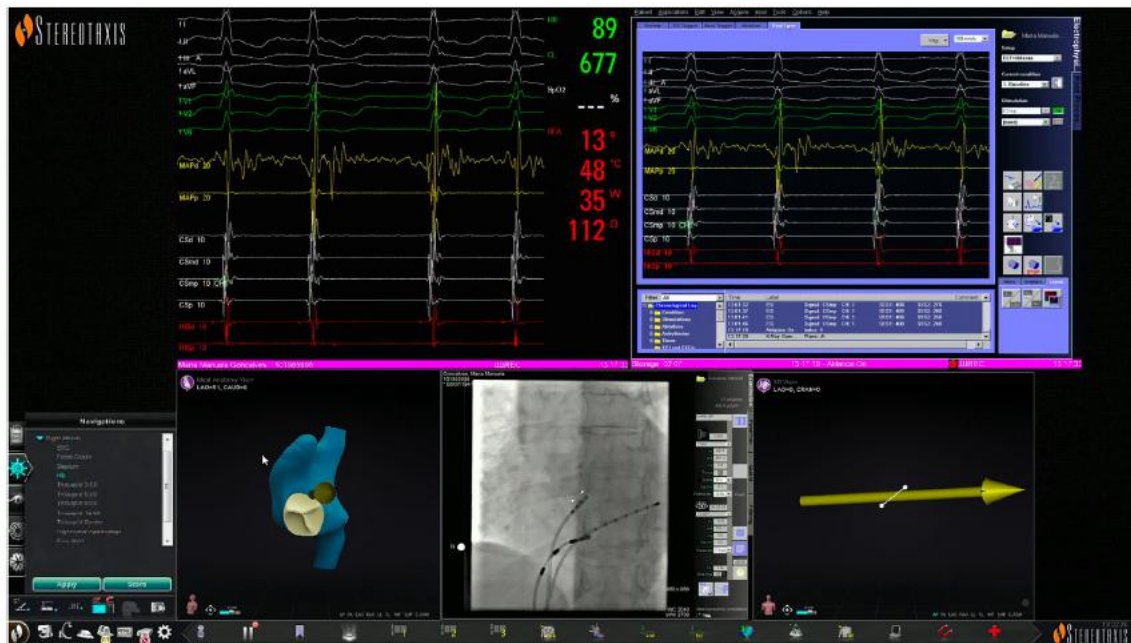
Navigant workstation screen: junctional rhythm during radiofrequency delivery (top panel); reference X-ray image in left anterior oblique view displaying the real-time position of the ablation catheter, His bundle catheter and His bundle location (white dots); the magnetic navigation system's automatic vector to slow pathway location (vector).
